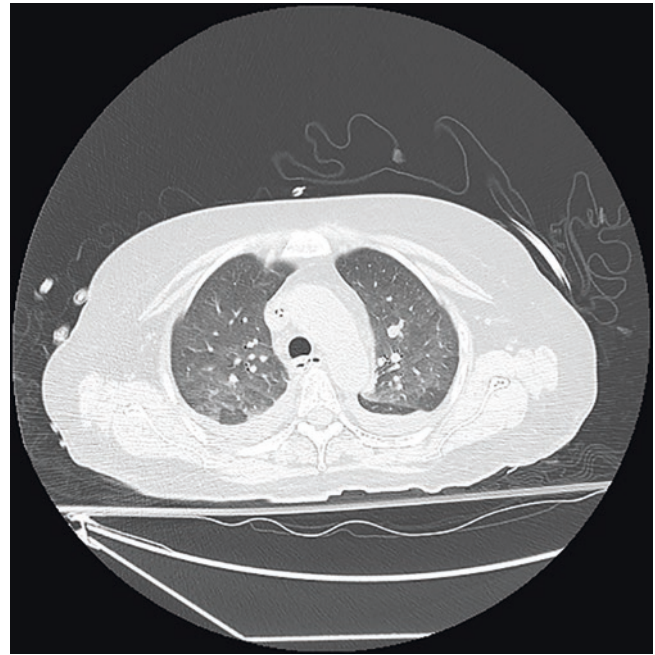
Computed tomography scan of the chest of a patient with pulmonary alveolar proteinosis shows patchy ground glass opacities in both lungs resulting in a “crazy paving” pattern; bilateral pleural effusions can also be noted
